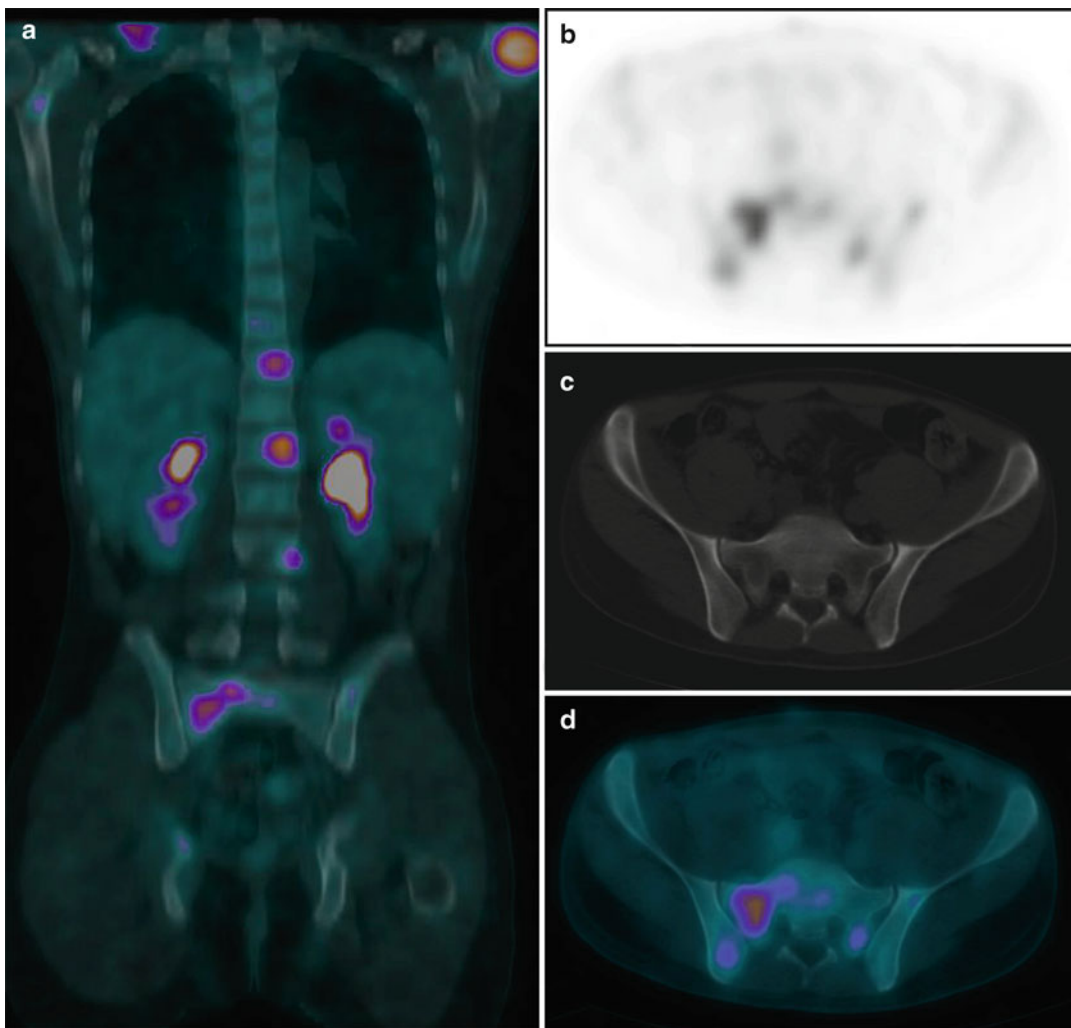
FDG PET/CT was performed in a 22-year old male for initial staging of Hodgkin's lymphoma and revealed multiple foci of bone marrow infiltration including the right scapula, the left humerus, multiple thoracolumbar vertebrae, and the sacrum. FDG-avid soft tissue tumor masses in the *right lower neck* and the mediastinum are not shown. Blind BMB performed on
